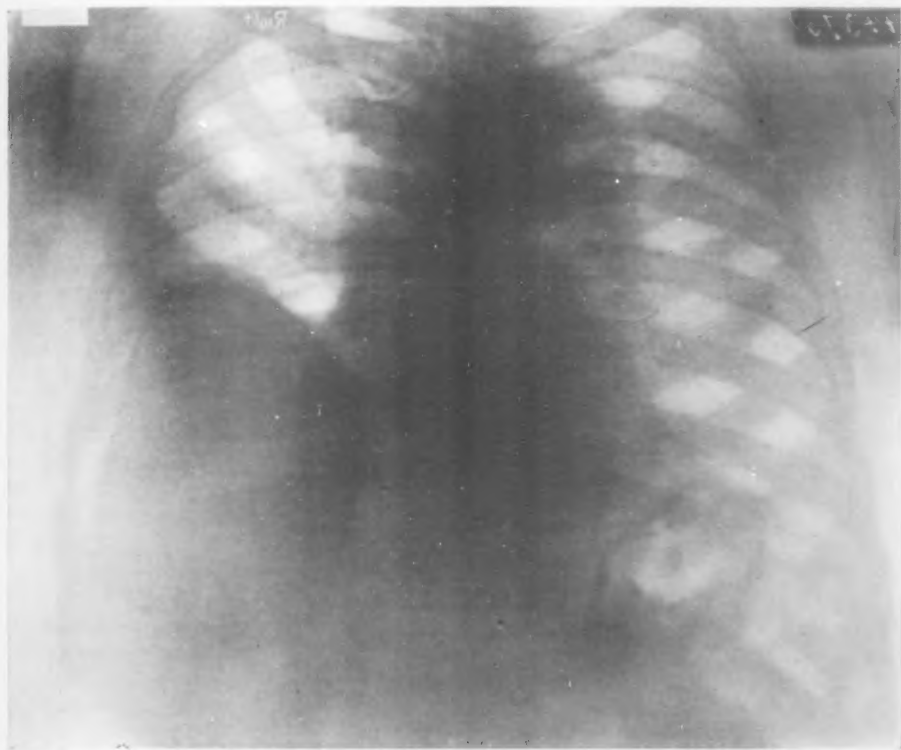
X-ray of Case I showing shadow of calcified cyst in right thoracic cavity.
